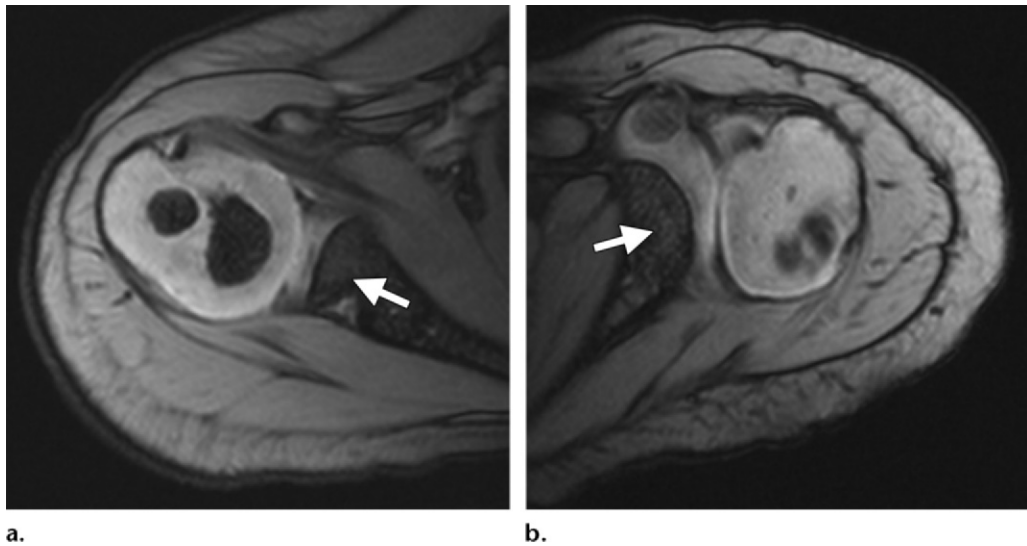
Shoulder dysplasia in a 19-month-old boy with left brachial plexus palsy. (a) Axial GRE MR image of the normal right shoulder shows a well-formed proximal humeral epiphysis with two partially ossified SOCs. There is a normal glenohumeral relationship with a well-formed glenoid (arrow). (b) Axial GRE MR image of the left shoulder demonstrates posterior-inferior subluxation of the humeral head, with glenoid hypoplasia (arrow) and a deficient labrum seen posteriorly. The humeral head is small, with delayed maturation of the SOCs.
